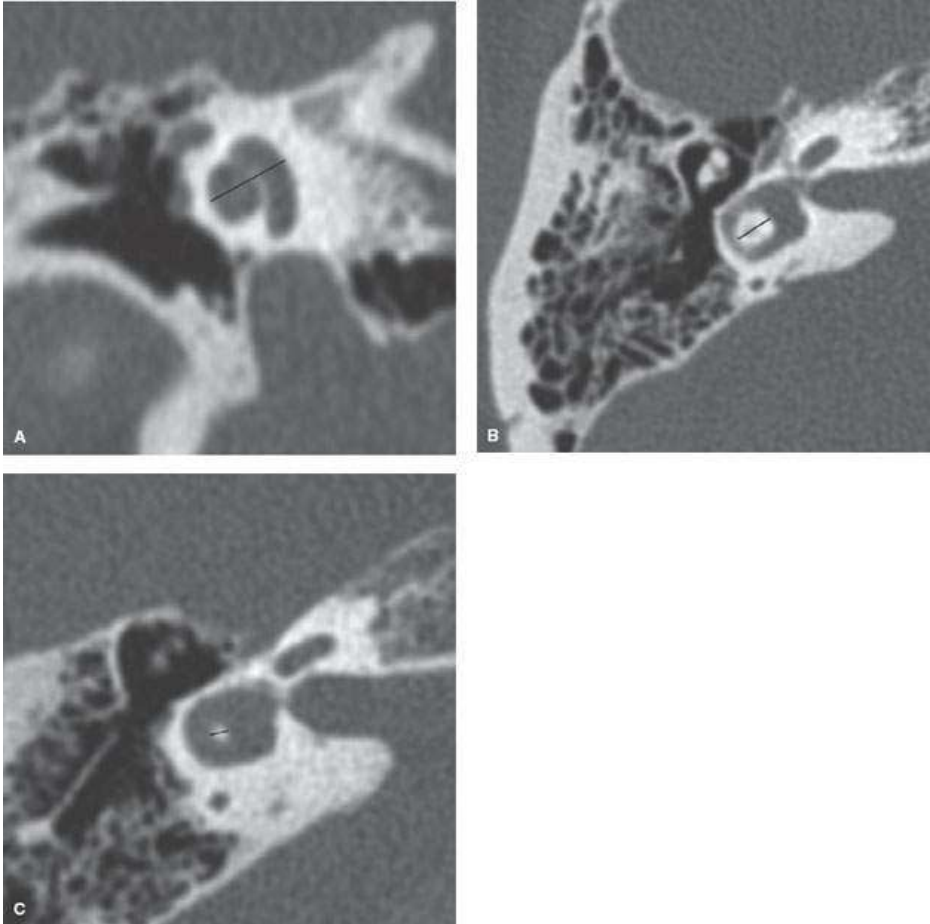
A, B: Standardized measurements of the inner ear on temporal bone computed tomography. The cochlear height is measured in a coronal section at an oblique angle (line). The lateral semicircular bony island width is measured on an axial image on a line connecting the apex of the canal's turn to the midpoint of the communication between the canal and the vestibule (line). C: Dysplasia of the lateral semicircular canal. The bony island measures 1.3 mm.
